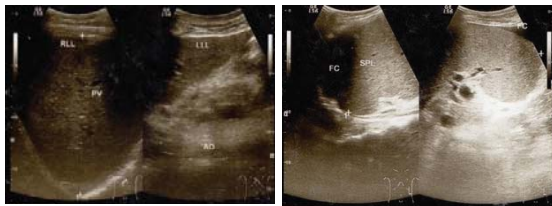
2 A: Abdominal ultrasound showed hepatomegaly with the size of 15.4 cm, blunted edges, regular surface, coarse heterogenic ecoparenchyma. Dilatation of portal vein was found with diameter of 1.3 cm (Portal vein velocity 9 cm/s); 2 B: Splenomegaly was also found, with diameter of 20 cm, blunted edges, flat surface, homogeny ecoparenchyma and dilated splenic vein (diameter 1.3 cm and splenic vein velocity 16 cm/s).
